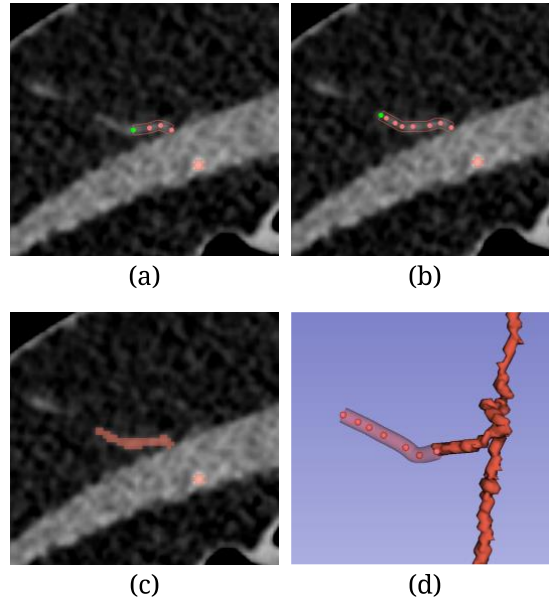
Manual segmentation of deep inferior epigastric artery perforators on a CTA scan. (a-c) Axial view of CTA scan where the tube wire function was used to perform the segmentation of the perforator vessels, (d) 3D view tube wire segmentation.
